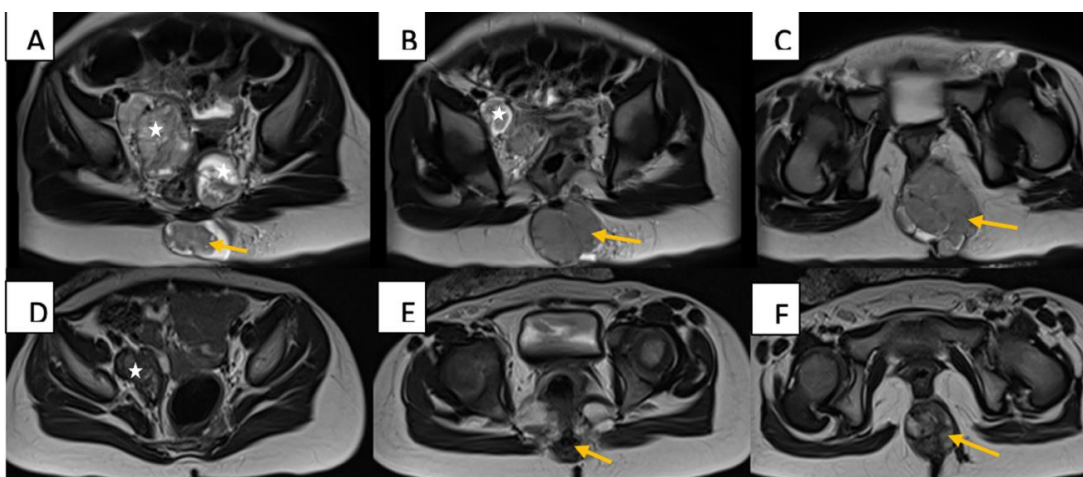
Baseline MRI (A–C) and post-chemotherapy follow-up MRI (D–F), axial T-weighted images, demonstrate a reduction in the size of the primary mass (arrow) and regional lymphadenopathy (asterisk), consistent with a partial treatment response
